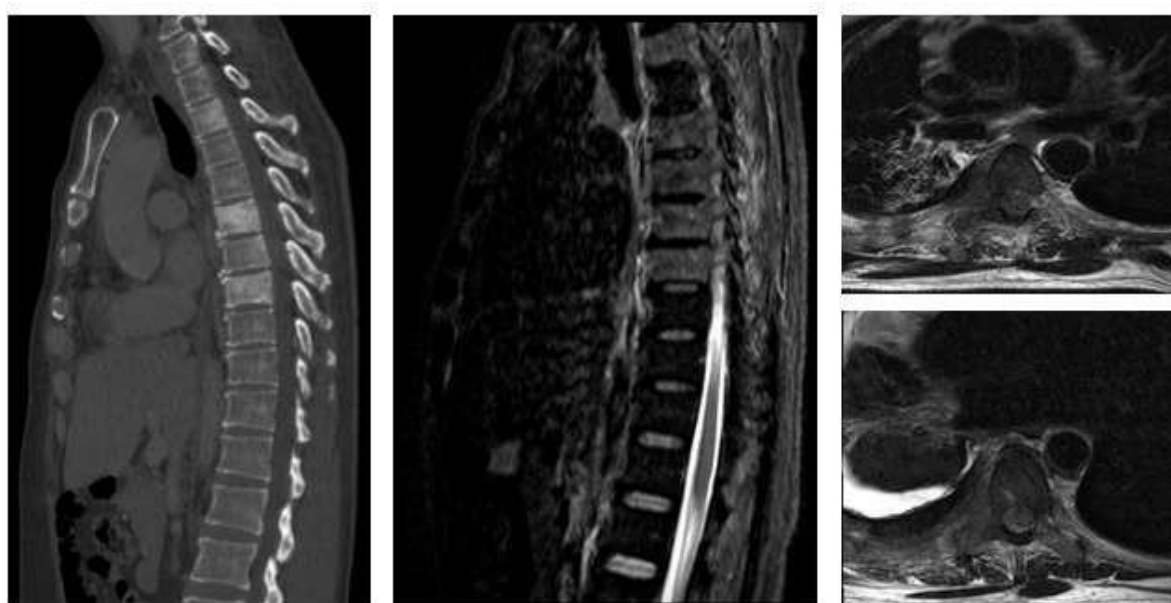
Sagittal CT and MRI of the thoracic spine show multifocal marrow-replacing metastatic lesions at T3 and T5–T8, demonstrating paravertebral soft-tissue extension, intracanalicular and intramedullary spread, and severe spinal canal stenosis with associated cord edema, including extension into the right T6–T8 ribs
